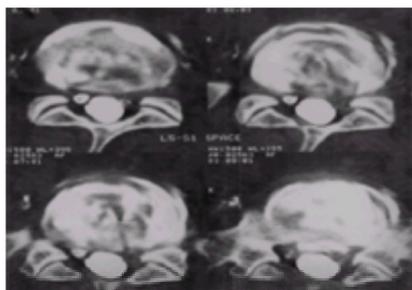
CT discoradiculography. The degenerate disc is demonstrated with total loss of the normal nuclear/annular configuration. The bulging disc is demonstrated centrally and on the left side of the canal. It is associated with facet hypertrophy and lateral recess stenosis. The soft tissue of the disc is only partially opacified by contrast in the left lateral recess, but there is non-visualization of the S1 root on the left compared with its normal visualization on the right.
